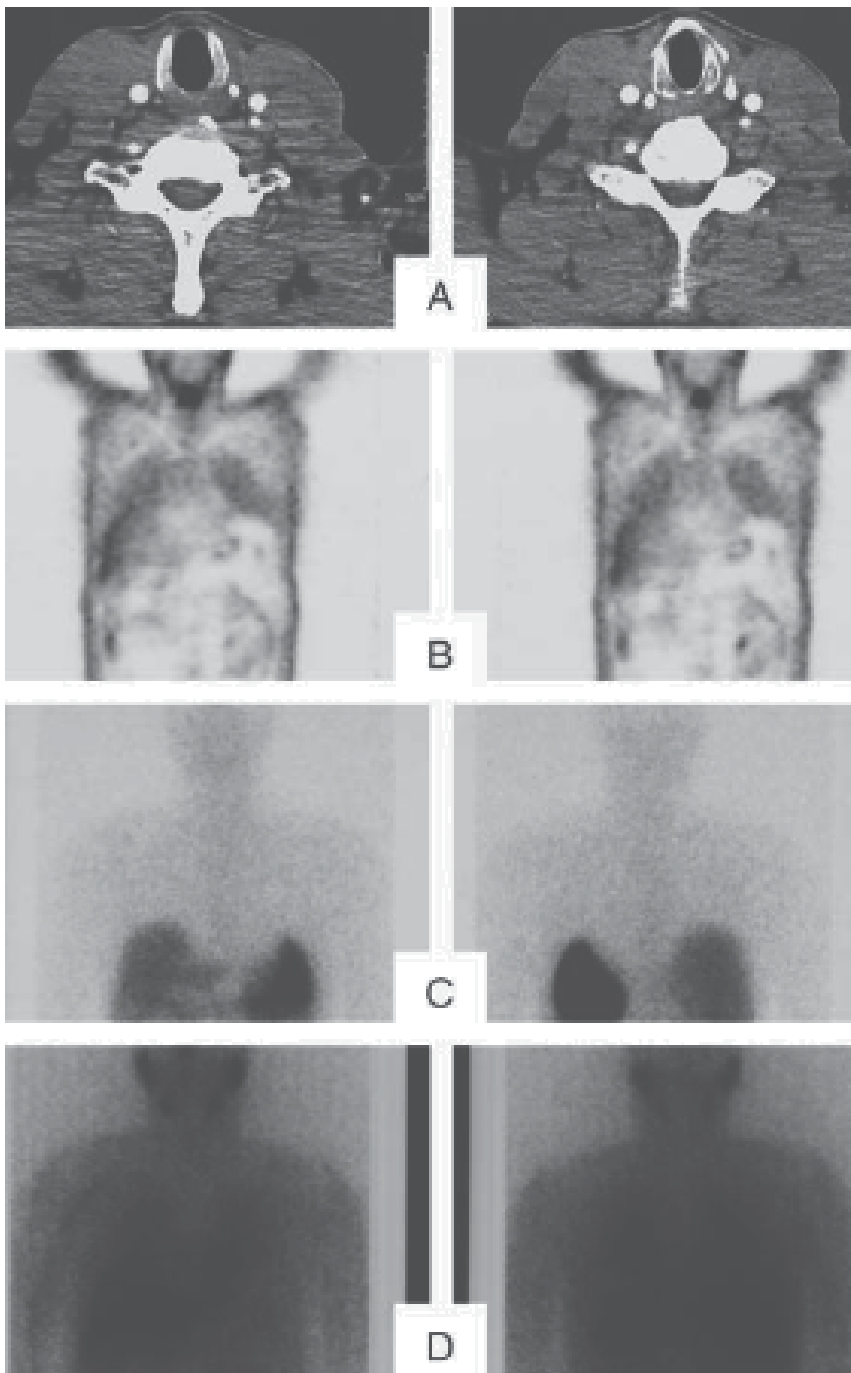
Lymph node metastases in a patient with postoperative persistence of medullary thyroid carcinoma (MTC) positive at FDG-PET (B) and negative at conventional imaging techniques (CT-scan [A], Octreoscan [C] and MIBG-scintigraphy [D]) (from Faggiano et al., 2009).
